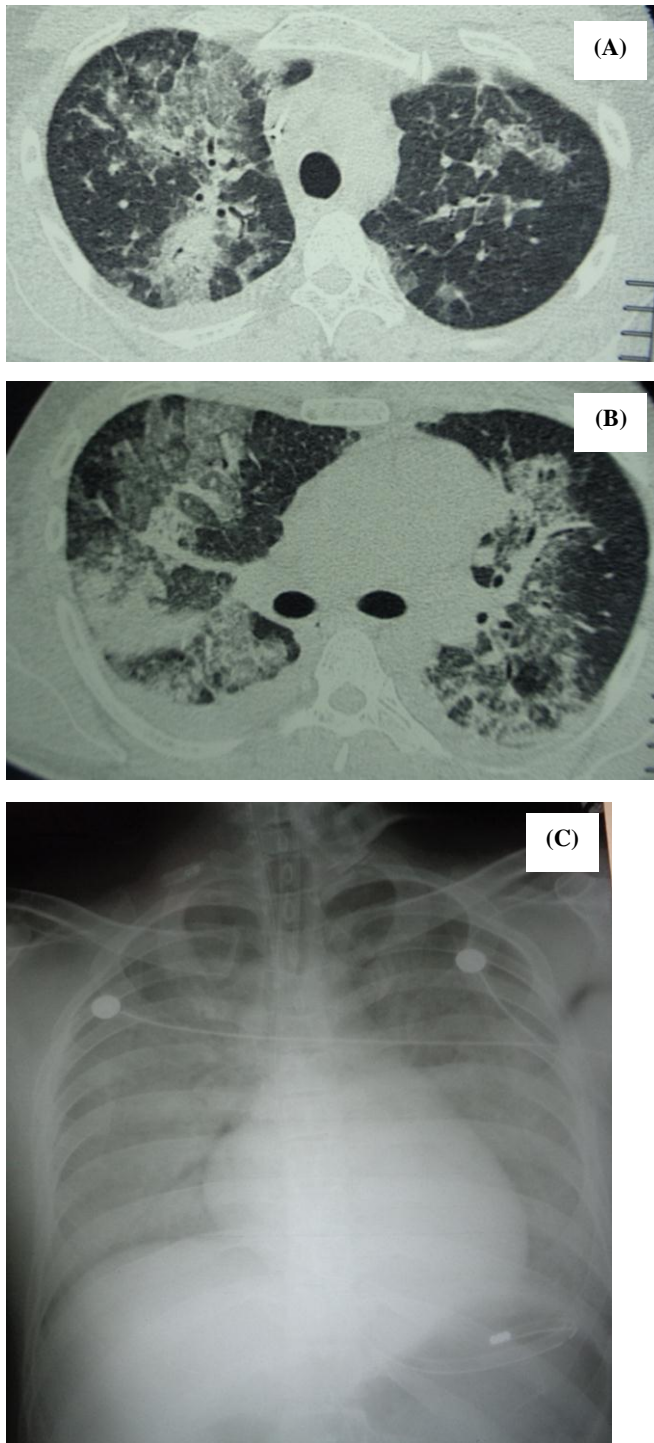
High-resolution computed tomography of chest (A, B) and chest x-ray (C) showing pulmonary hemorrhage on day 5 of snakebite
